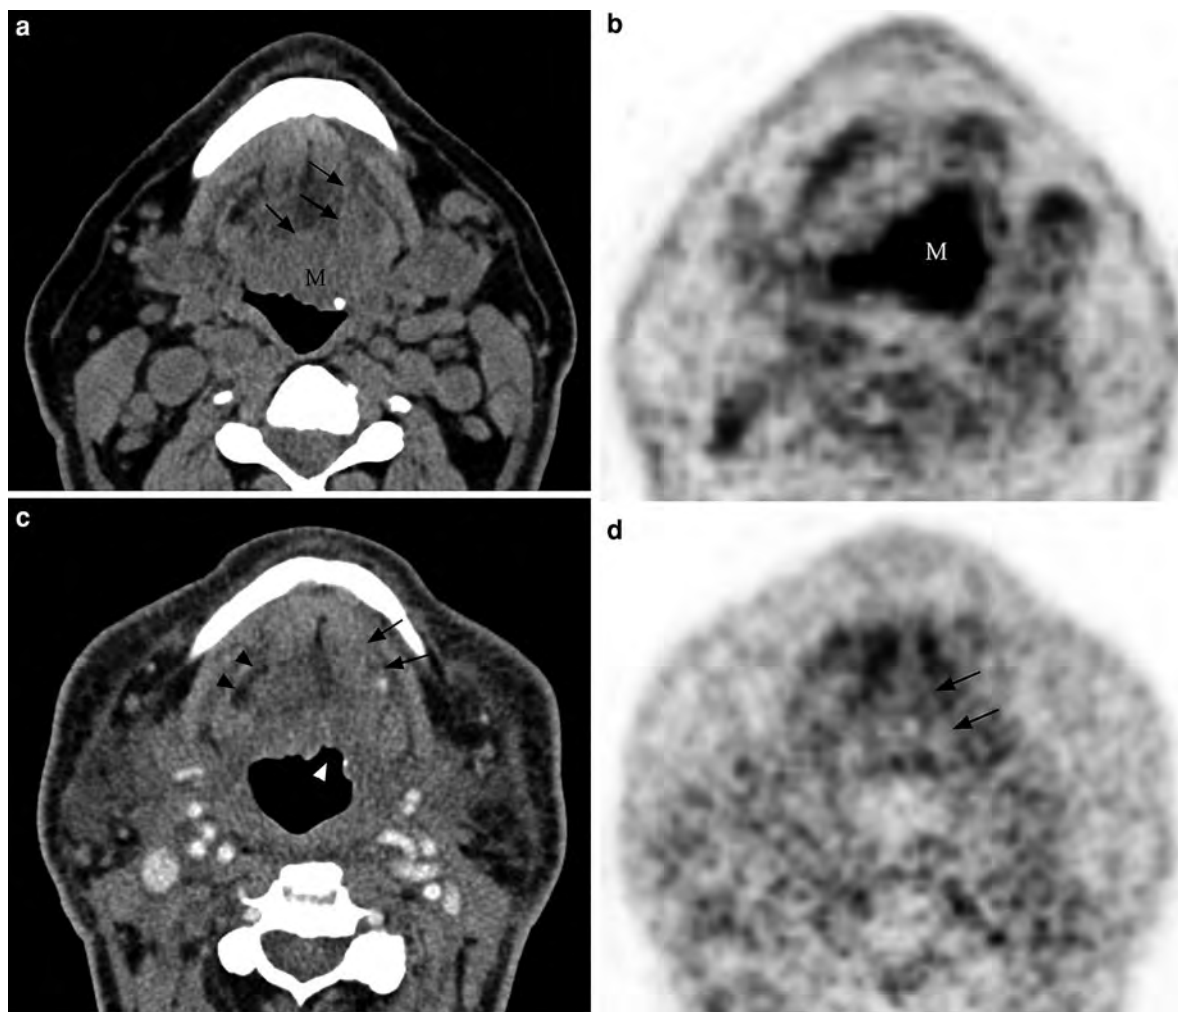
Non-contrast enhanced CT image (a) in a patient with dysphagia shows a large mass involving the tongue base bilaterally (M in a) with signs of deep infiltration in midline and on the *left side* (arrows in a) with profound FDG uptake (M in b) on the PET image (b) that also involves the entire right tongue base. The contrast-enhanced CT image (c) performed 3 months after completion of radiation therapy demonstrates a
